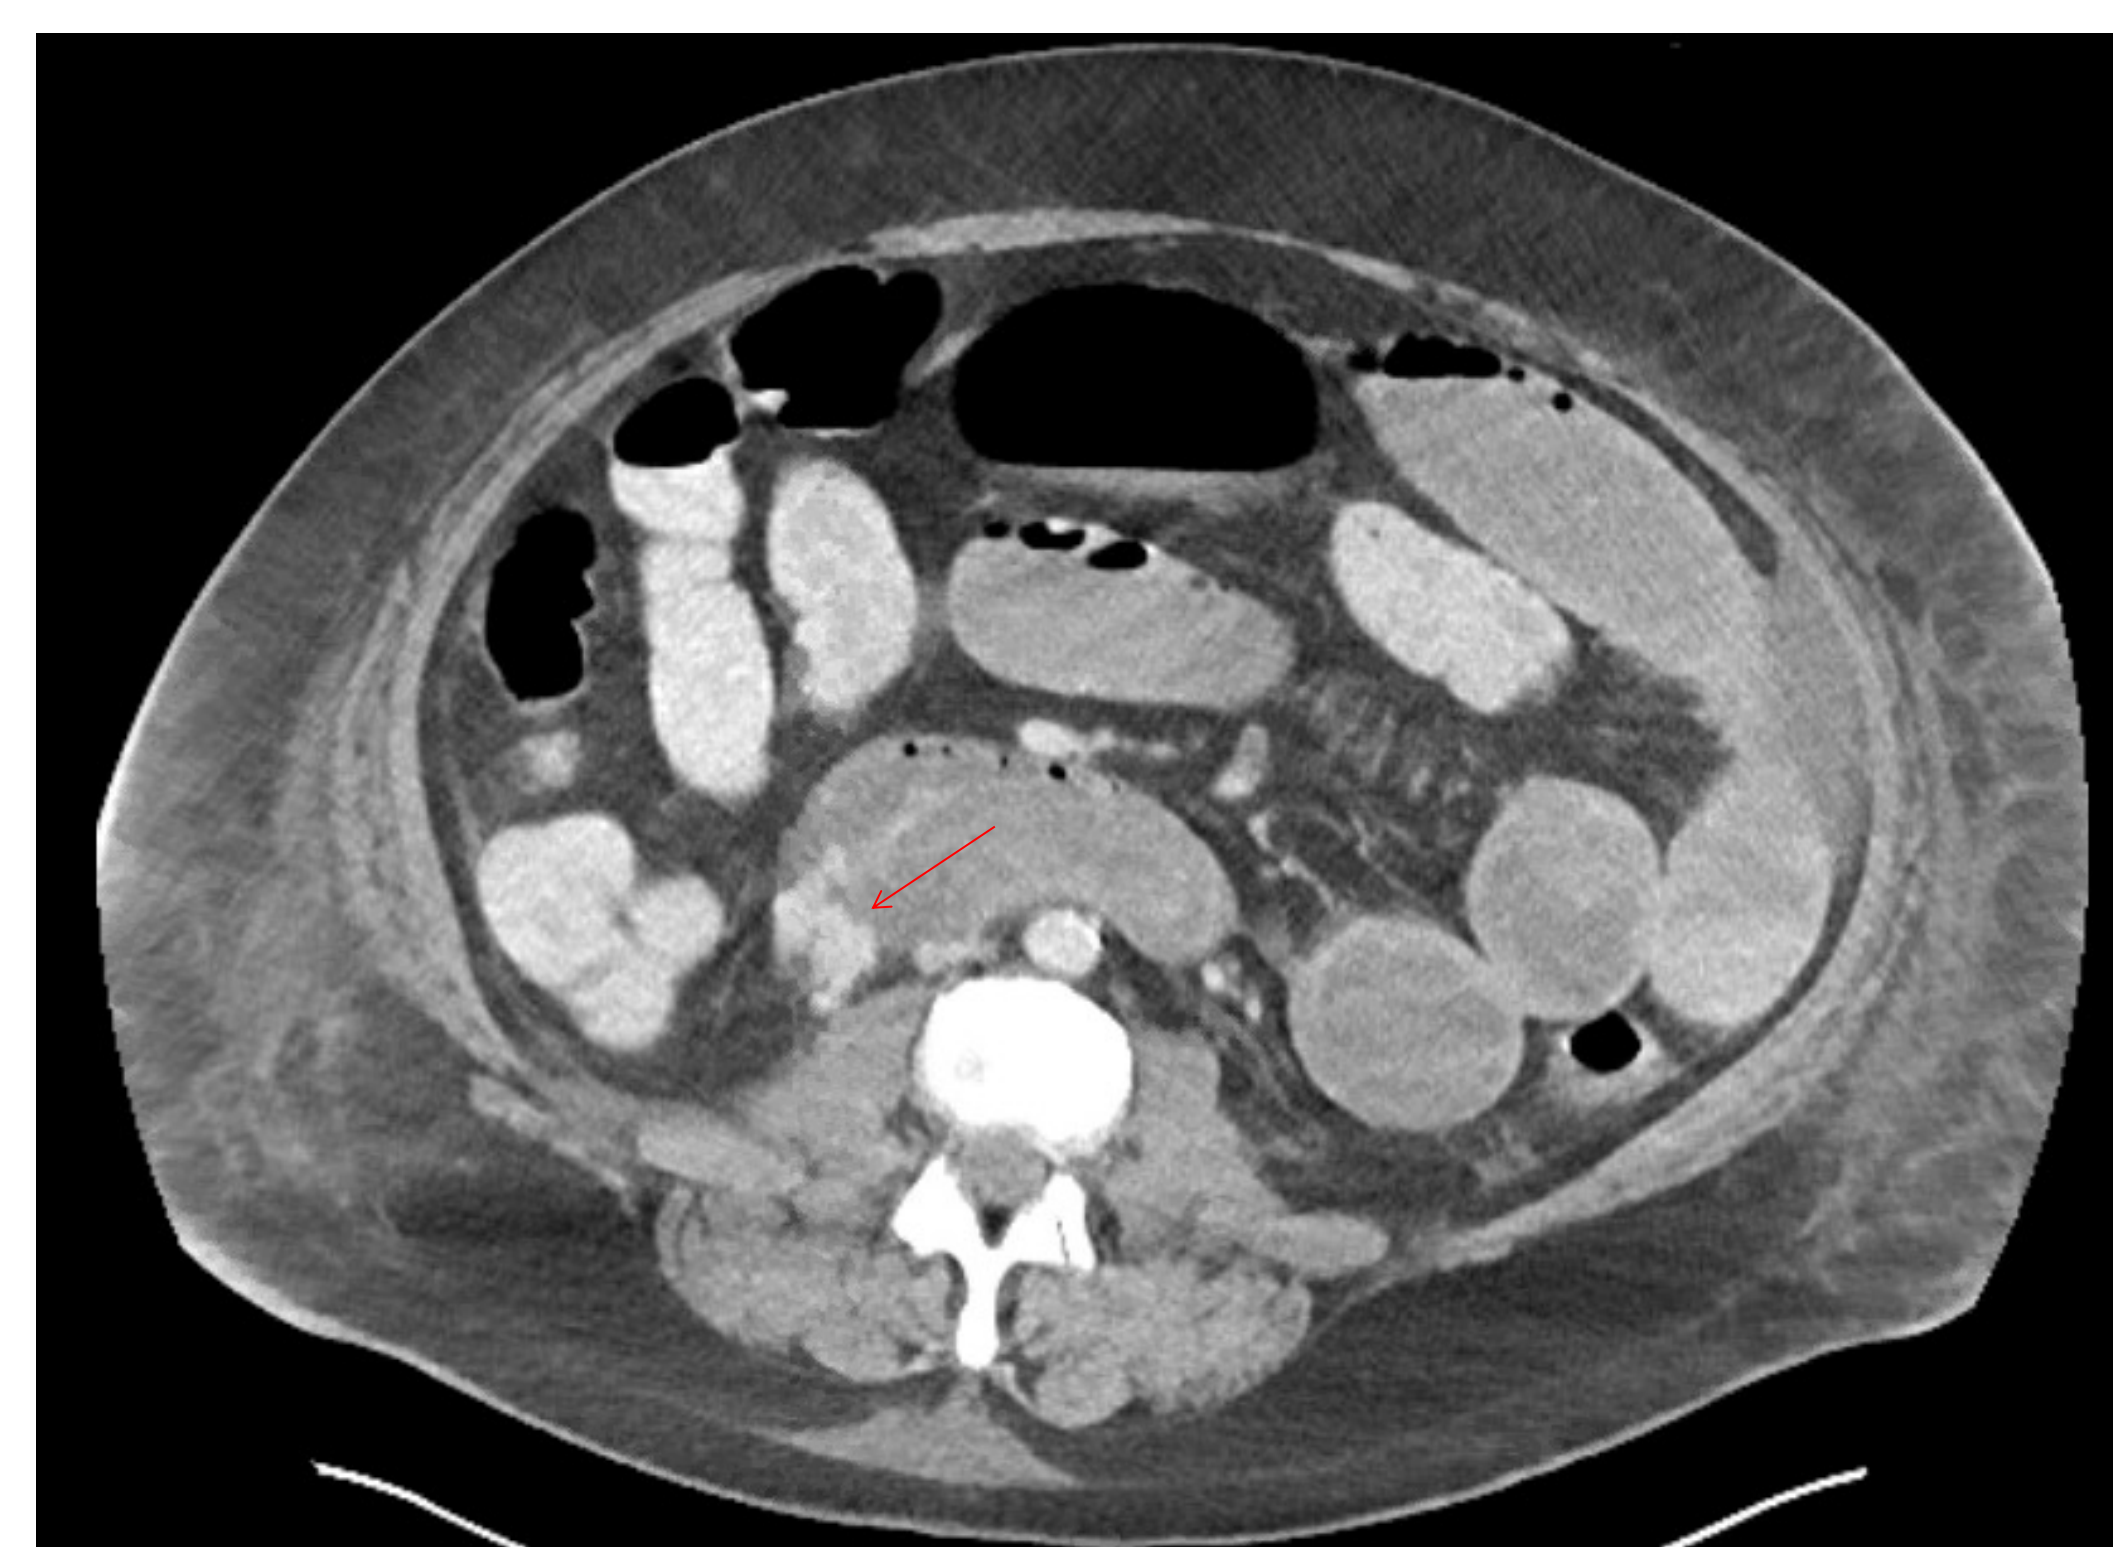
CT angiography showing a large duodenal varix with active hemorrhage into the second portion of the duodenum (red arrow).
